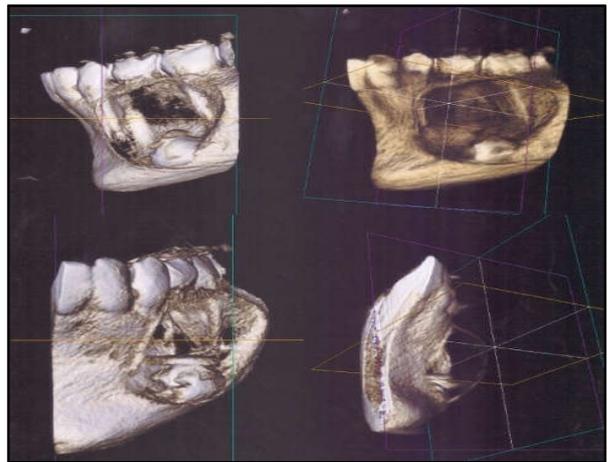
CBCT of the patient
